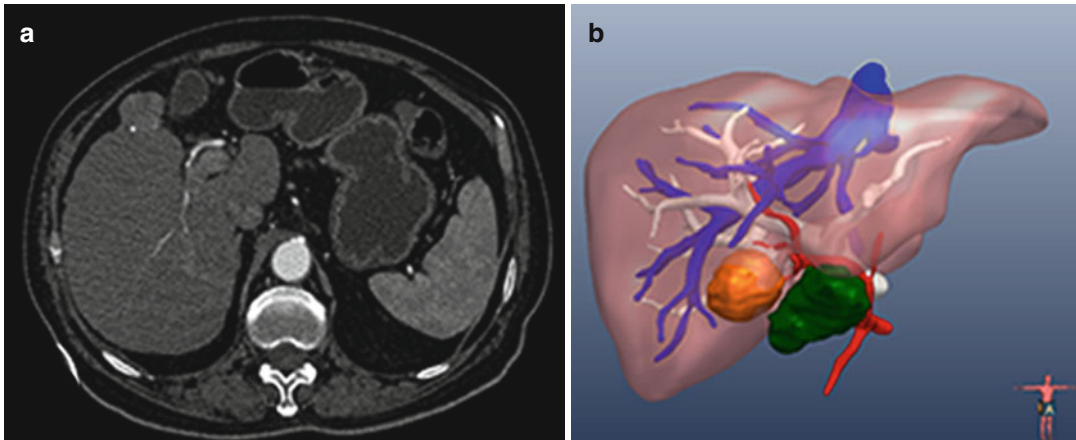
2D CT image and the relevant 3D images. (a) The original CT image of the patient. (b) The surface rendering image of the liver (*brown*), the tumor
